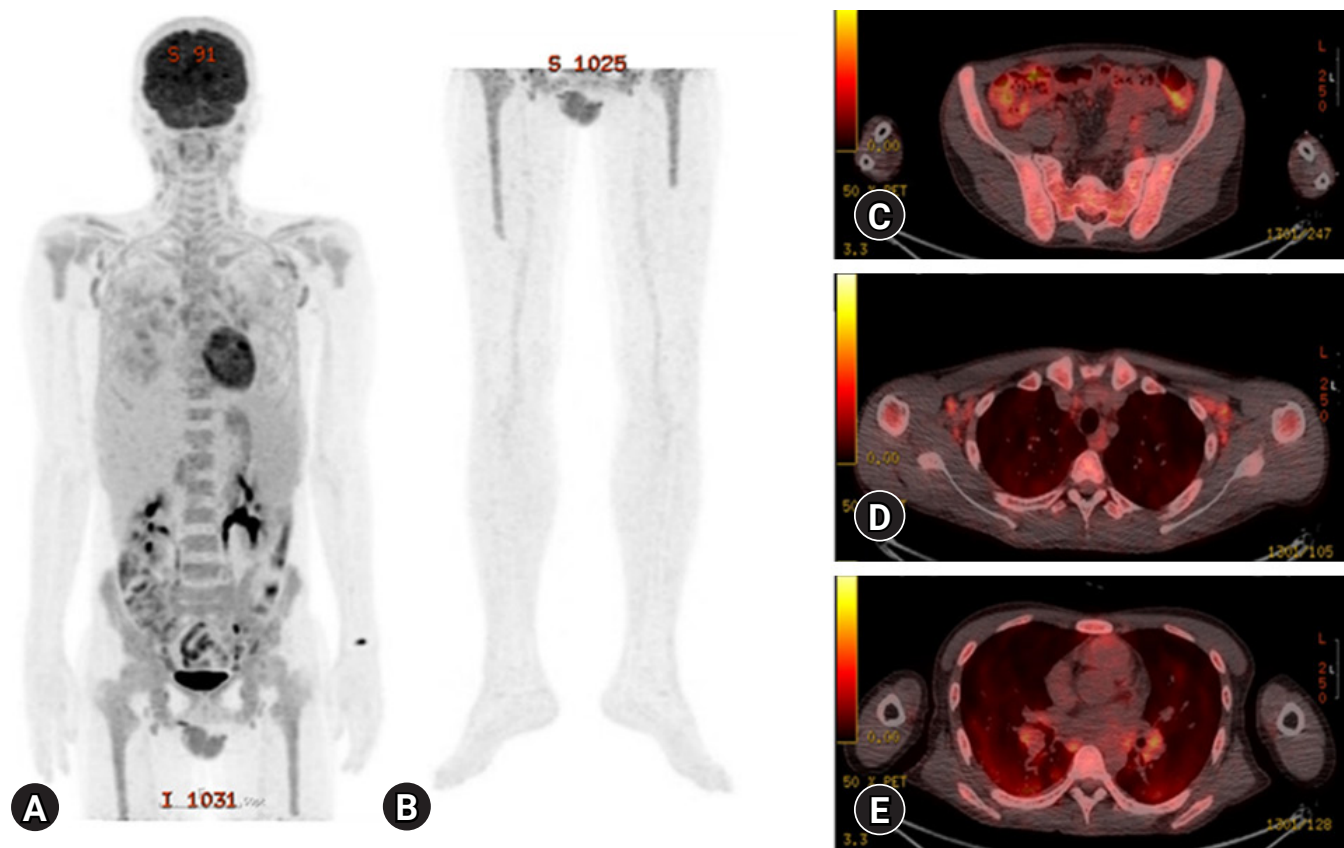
(A-C) Diffusely enhanced ^{18}F -fluorodeoxyglucose uptake is seen in the bone marrow of shoulders, pelvis to femurs, (D) both axillary and both paratracheal lymph nodes, (E) and lung parenchyma with multiple cystic lesions and both prevascular lymph nodes on a positron emission tomography-computed tomography scan.
